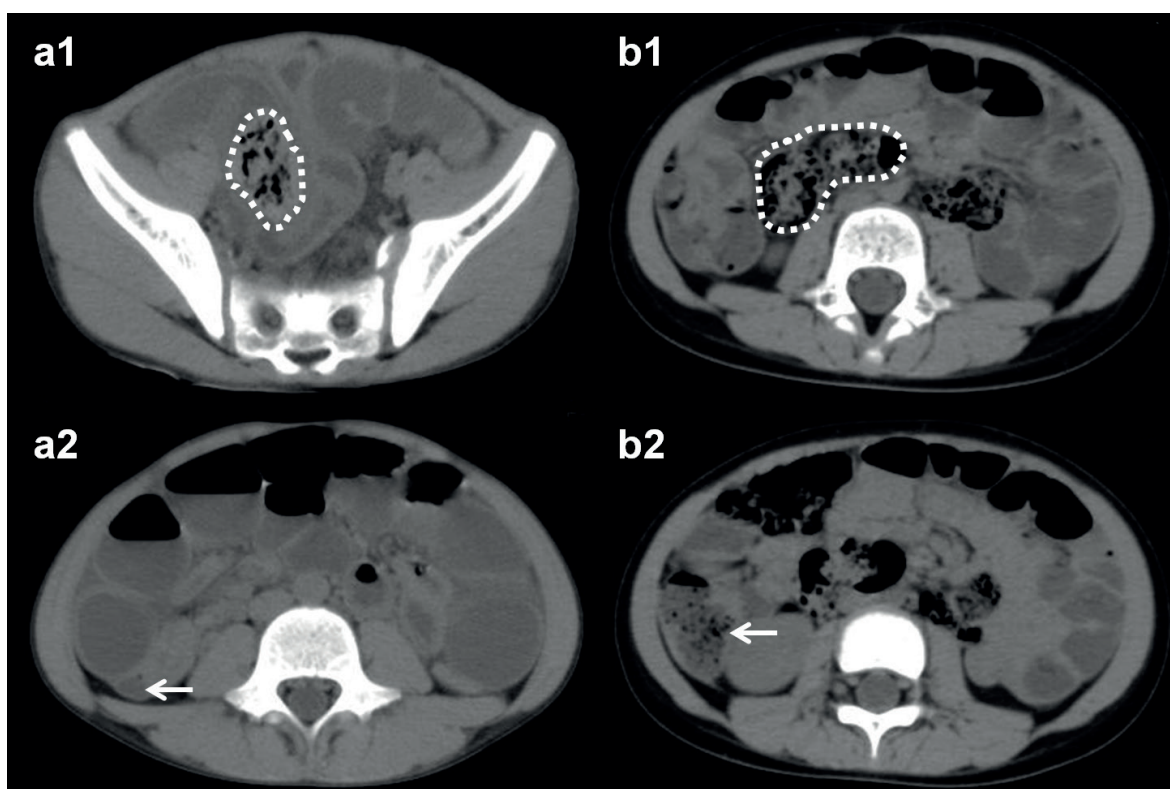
The differences of unenhanced CT features between phytobezoar and feces in two children with small bowel obstruction. a1, a2: A 11-year-old boy was diagnosed with phytobezoar-related obstruction. The size of the intraluminal mass measured about 3.2×2.8 cm, and mean attenuation was 11.4 HU (a1, dotted outline). Only minimal liquid was seen in the ascending colon (a2, arrow). b1, b2: A 3-year-old girl was diagnosed with incomplete obstruction. The size of the food debris was about 4.8×2.6 cm, and mean attenuation was 2.1 HU (b1, dotted outline). A moderate amount of gas and stool was observed in the ascending colon (b2, arrow).
